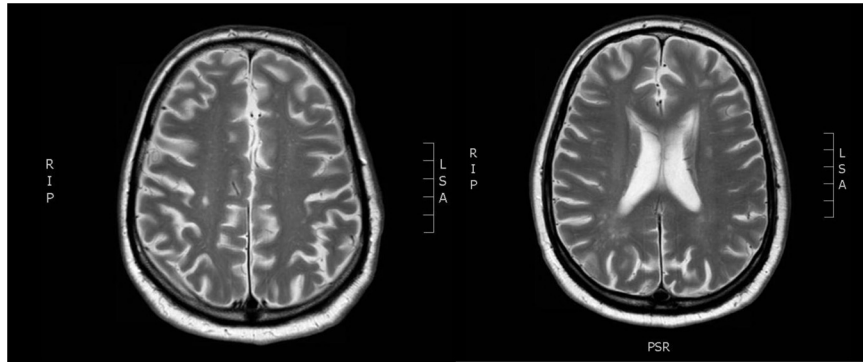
Magnetic resonance imaging scan of the brain was consistent with right parietal and occipital lobe small acute-to-subacute ischemic infarcts.
